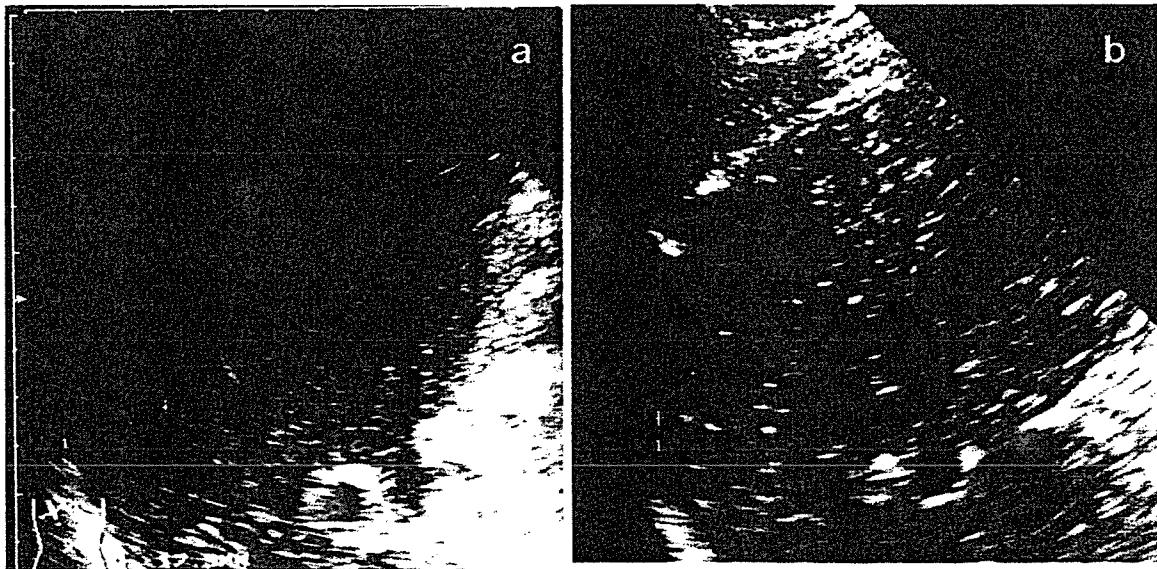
Ultrasonographic findings of a well-differentiated hepatocellular carcinoma (a) before and (b) after intra-arterial enhancement with carbon dioxide gas.
